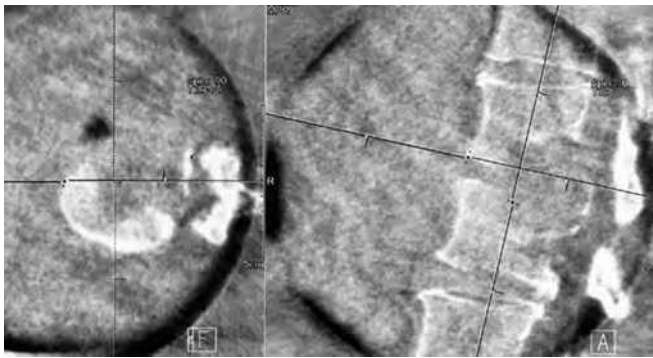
Snapshot of intraoperative computed tomography after anterior decompression surgery.
